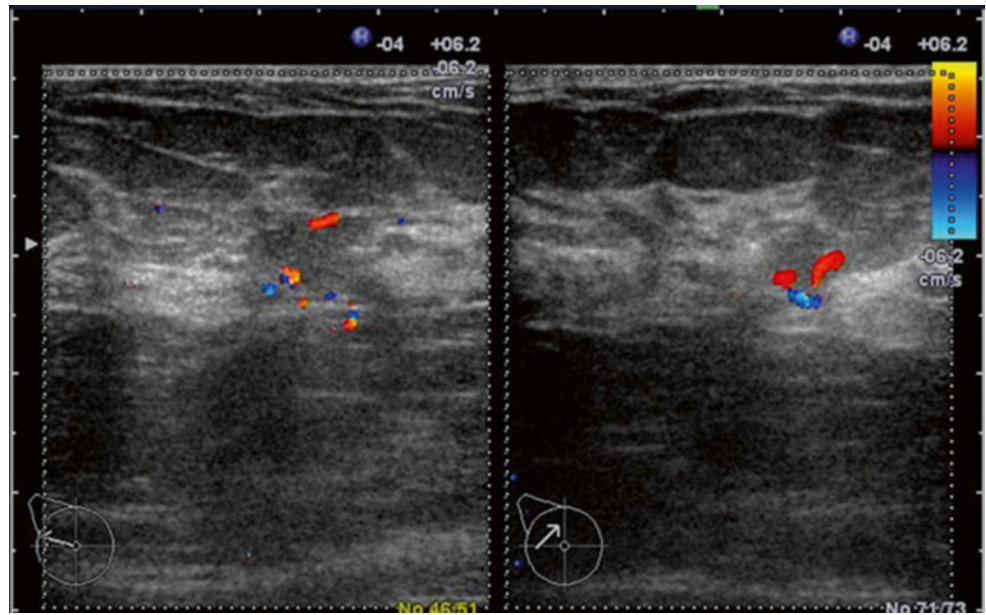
Benign calcification of 0.9 mm, in a TDLU location, typically for a calcified lactiferous cyst; Doppler DE confirms beside the dimension, shape, location, and the absence of the new formation vessels, conclusive for the benign lesions; the acoustic shadowing is due to the Cooper ligament, these calcifications being too small for producing posterior effects
